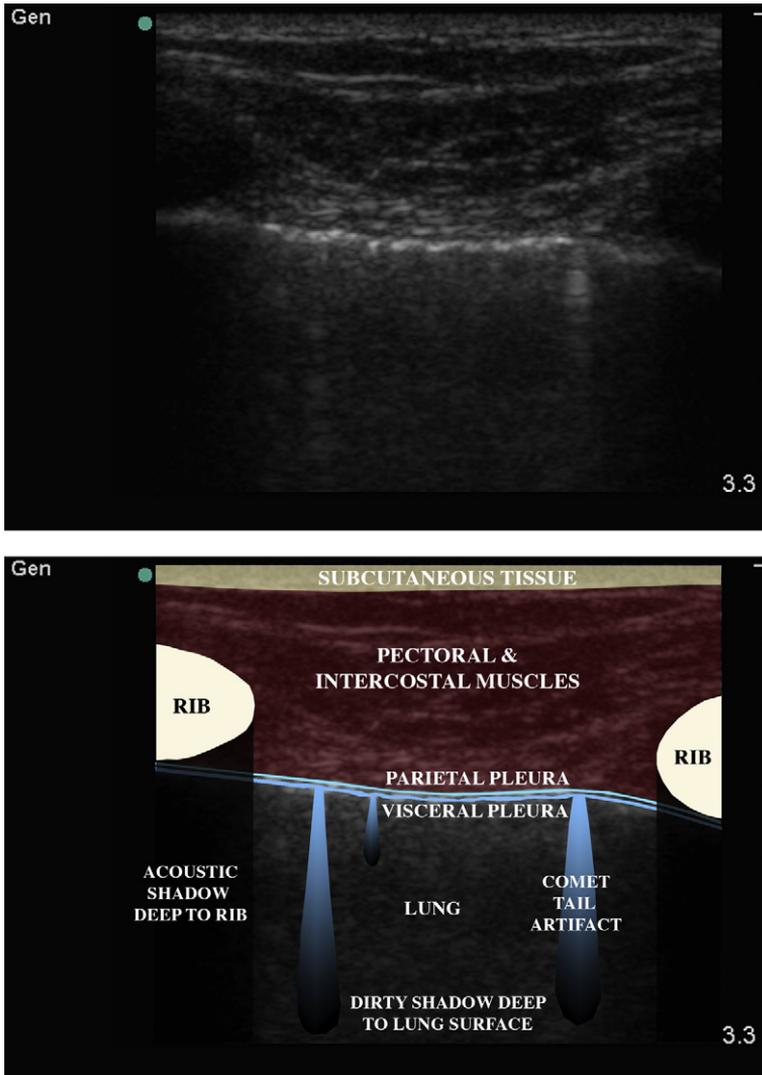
Normal pleural ultrasound showing the pleura as bright plane with comet tail artefacts.
